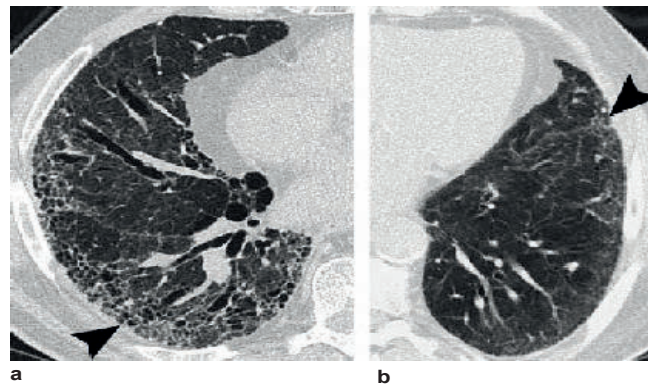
Comparison of high-resolution CT features between UIP and NSIP [28]
